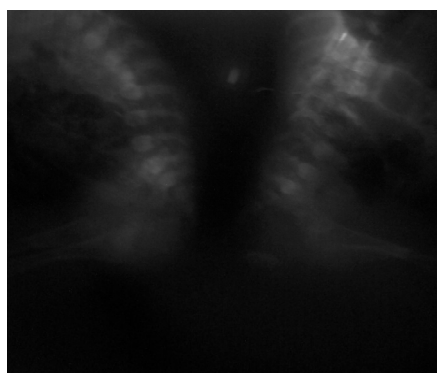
Plain radiograph showing two separate spinal columns.
